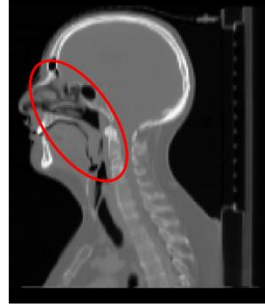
The pCT of patient 4 and the results of the intra-patient registrations for a single CBCT (middle row) and the mean of all CBCTs (bottom row). On the right, the CBCT and average CBCT (green) are superimposed over the pCT (pink). The region circled in red shows the area where the registrations were seen to struggle.
